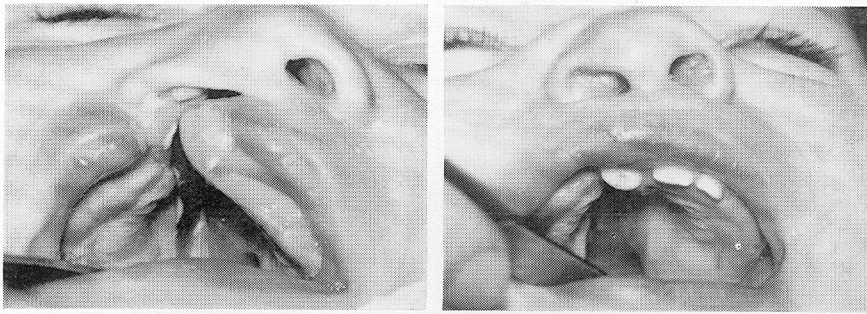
Left, a three-month-old boy, when the cleft of the primary palate was repaired (June, 1964) using periosteal flaps as described in text. Right, condition 10 months after the operation. Note accurate alignment of maxillary segments. X-rays show that the abnormal position of 1+ was present already before eruption and prior to surgery.
